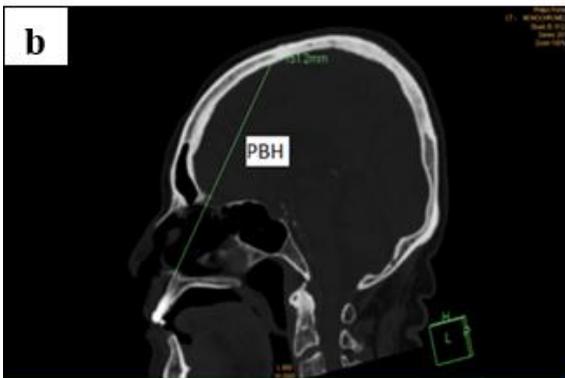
CT image showing the PBH
